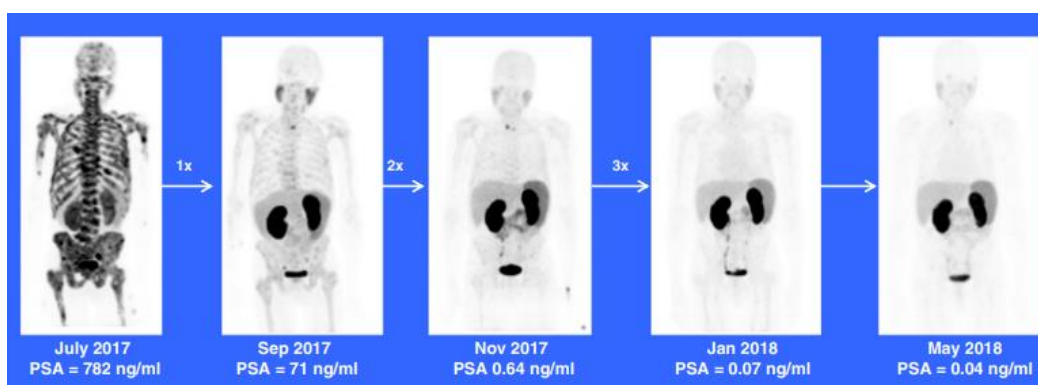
a treatment-naïve patient who presented with extensive bone metastasis at primary diagnosis achieved a complete remission after three cycles of ^{225}Ac -PSMA-617
